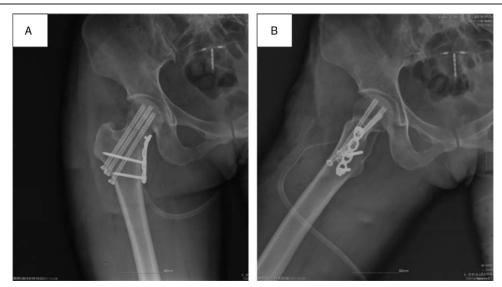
Postoperative x-ray examination showing good location and reduction of the femoral neck and head.
